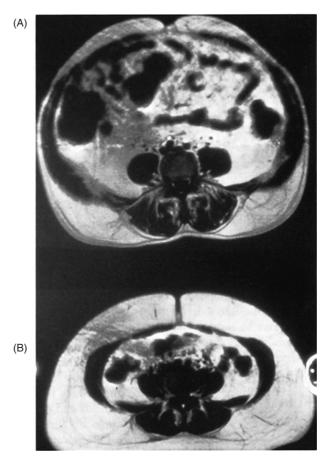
Cross-sectional images of the abdomen obtained by MRI. (A) Small subcutaneous fat area and enlarged visceral fat area. (B) Small visceral fat area in comparison with subcutaneous fat depot.
